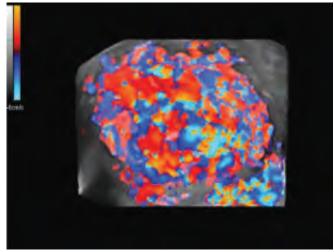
3D color-Doppler flow mapping of figure 11.20 tumor which shows rich blood flow covering the surface of tumor
